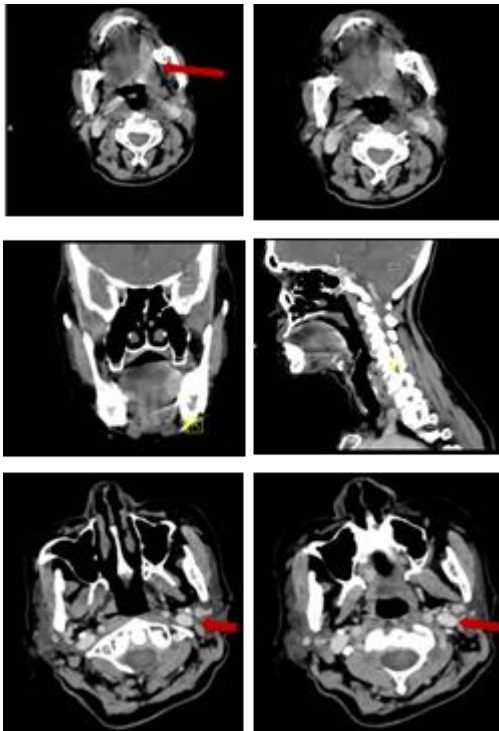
Contrast-Enhanced Oropharynx CT Scan Showed a Locoregional Lymphatic Spread to The Neck.
